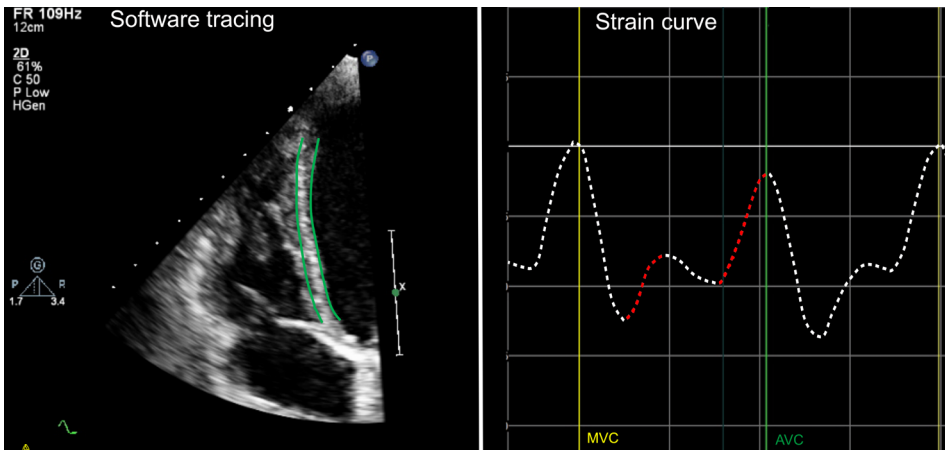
Acquisition of systolic rebound stretch of the septum on septal single wall image. Strain curves of the focused LV septal wall image derived with dedicated speckle tracking echocardiography software. SRSsept (in red) is defined as septal stretching after initial shortening. The apical cap is excluded from speckle tracking analysis. AVC: aortic valve closing, MVC: mitral valve closing
